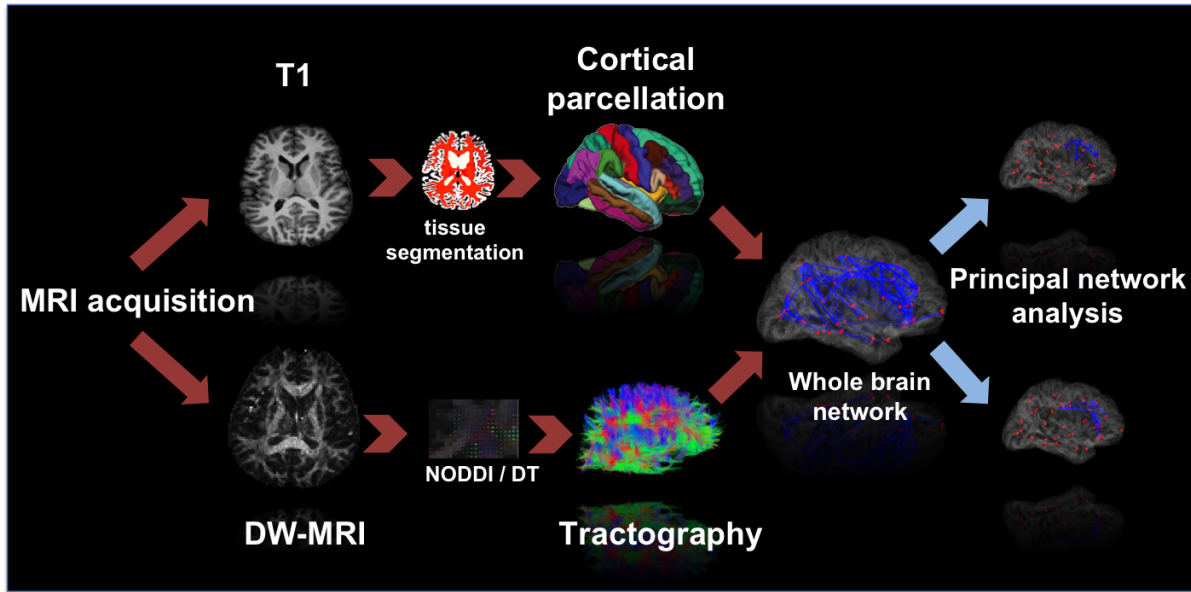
Extraction of whole brain structural connectivity network and principal network analysis. A T1 weighted image is used for segmentation and cortical parcellation and a DW-MRI image is used for tractography. The parcellation and tractography are then combined to derive the whole brain structural connectivity network. Influential subnetworks are then extracted from the whole brain network using PNA.
